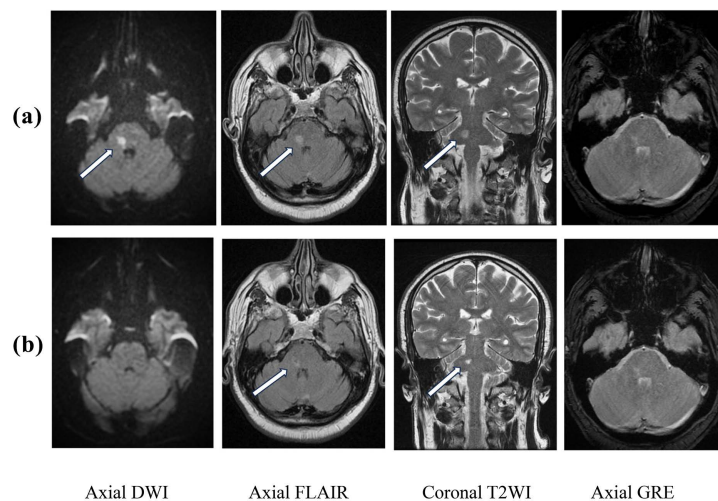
MRI of the brain at; (a) 1-week post-CVA showing 6×10 mm early subacute pontine infarct (Arrows) as shown by marked restricted diffusion in DWI images with slightly high in FLAIR and T2WI, and (b) 3-months later showing reduction of its size to 4×5 mm and encephalomalacia with peripheral gliosis (negative lesion on DWI and depicted focal change in FLAIR & CORONAL T2WI). Axial GRE is negative for bleed in both MRI.
